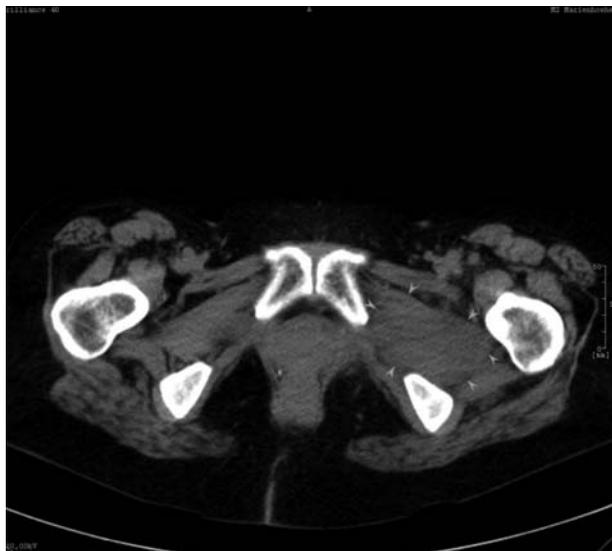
Initial CT, 8 days post-op.
